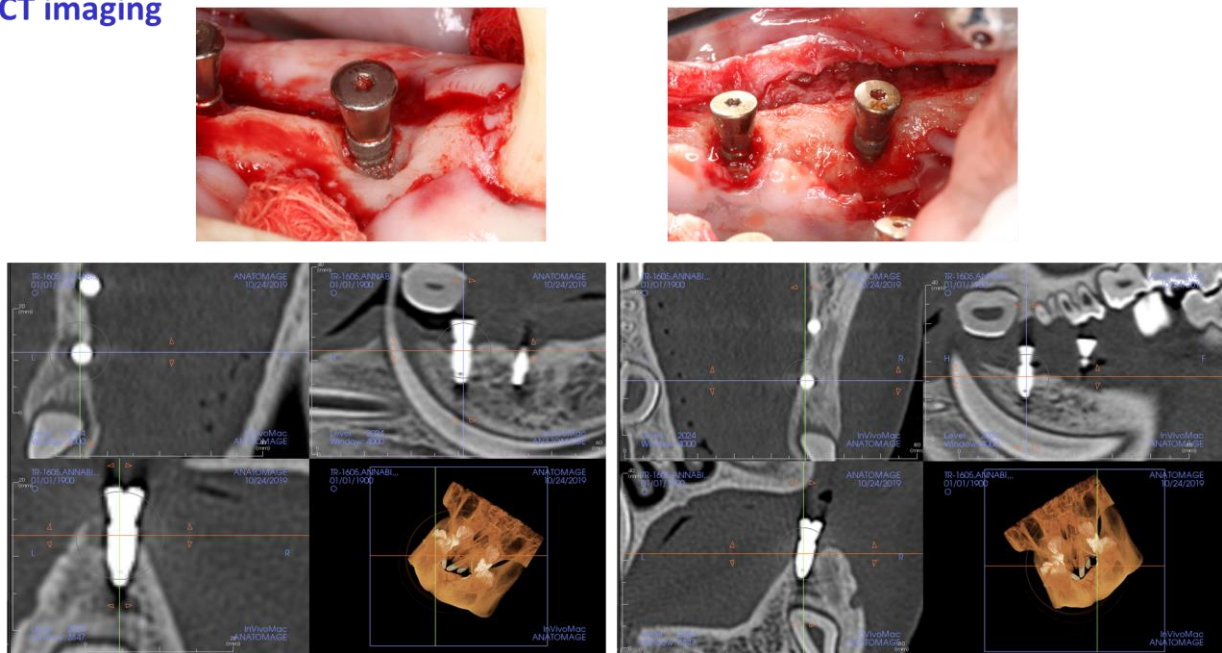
Representative photographic and CT images of the implants 3 months after ligature placement. A significant bone loss was observed around the implants.
